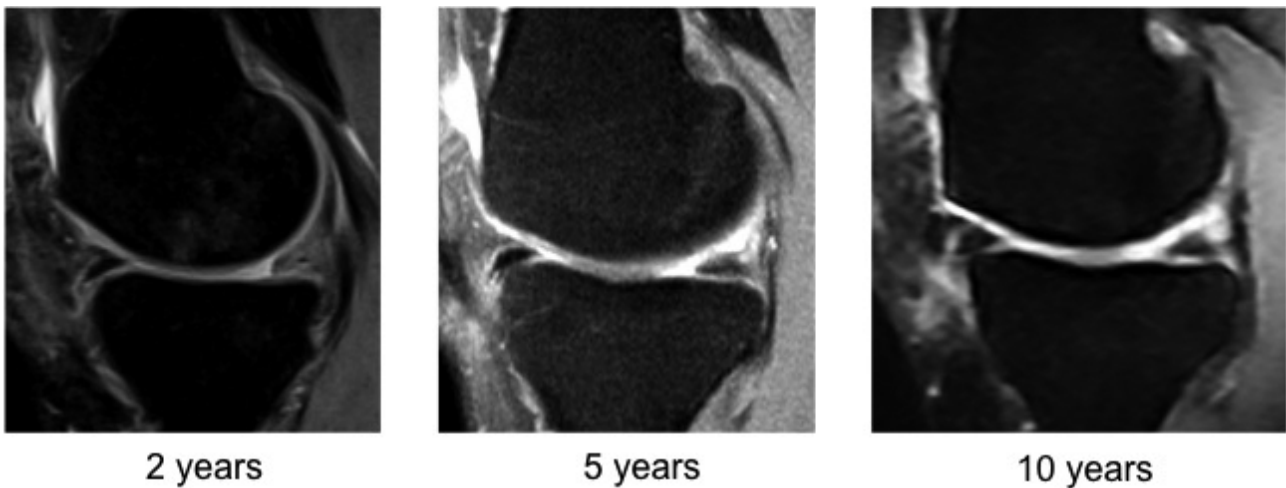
The MRI signal matures progressively. It becomes more homogeneous and the signal intensity decreases progressively, but at 10 years after surgery it is generally not completely similar to a normal meniscus.*
